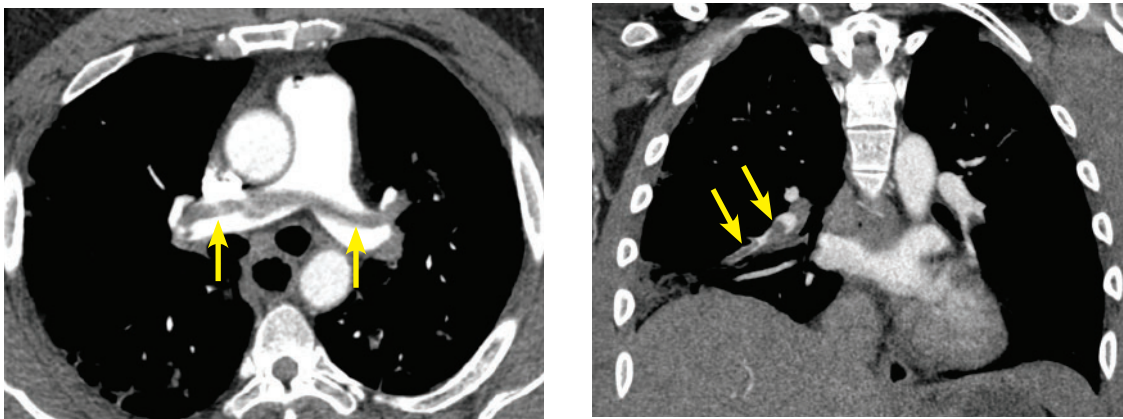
CT images of 2 different patients with COVID-19 demonstrating pulmonary embolism.
